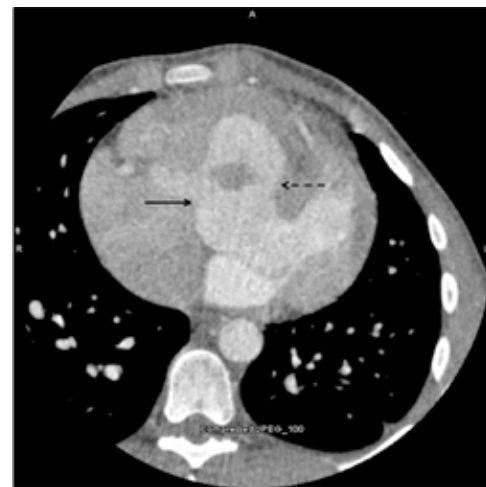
Axial CT demonstrating perimembranous (dashed arrow) and subpulmonic (arrow) VSDs.
